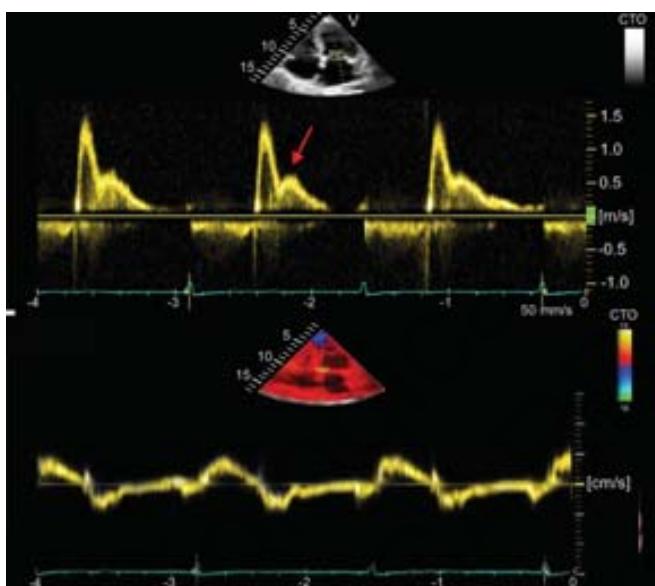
Pulsed-wave Doppler mitral flow in upper panel showing prominent L-wave (red arrow), no A-wave, and bradycardia.
